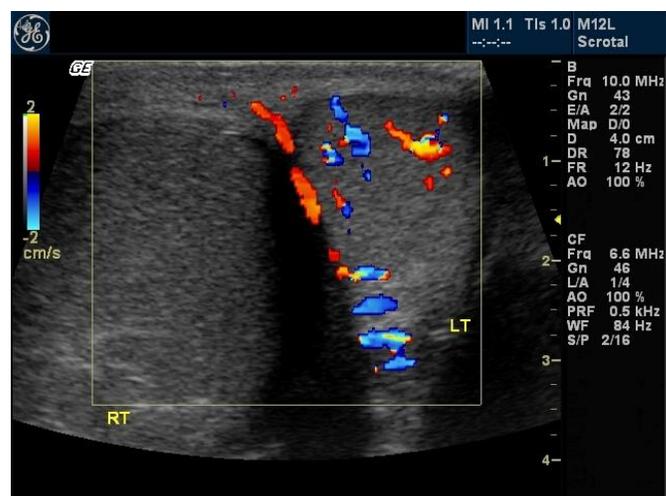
Color Doppler ultrasound (transverse plane, mid testis) showing no detectable flow in the right testis.
